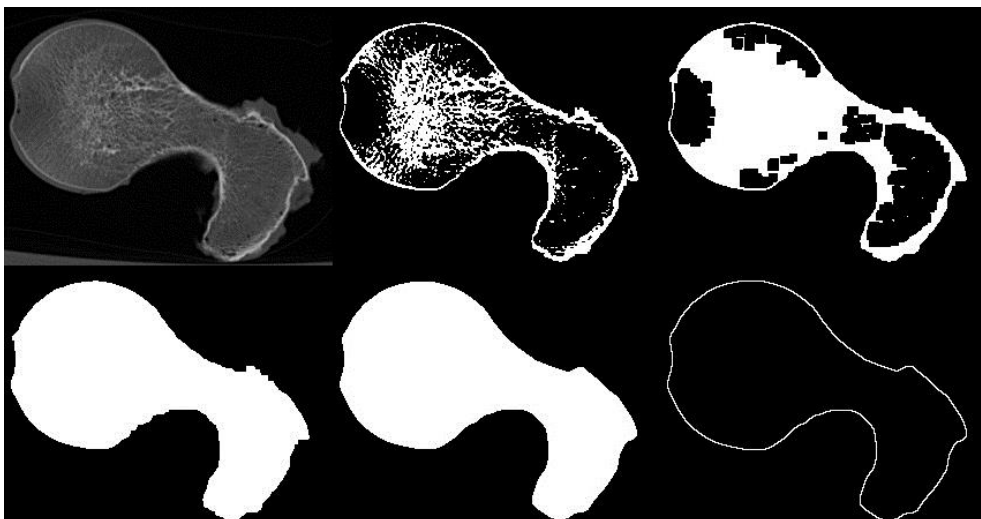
Segmentation of the CT images.
